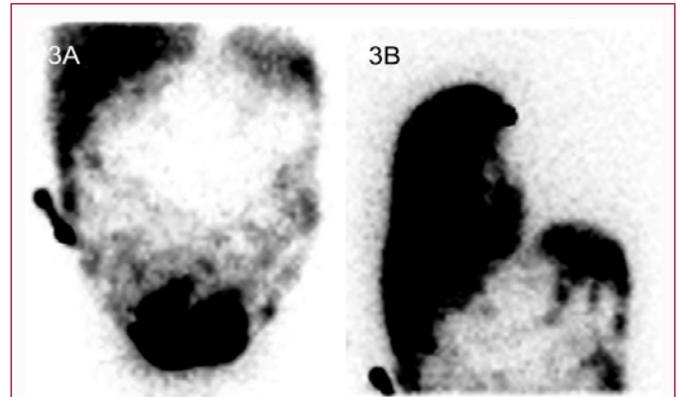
and 3B: Peritoneal scintigraphy showed there was an increased uptake of radio-tracer in her right lung within 5 min after the tracer injected into her peritoneal cavity, indicating presence of right sided pleuro-peritoneal communication.
